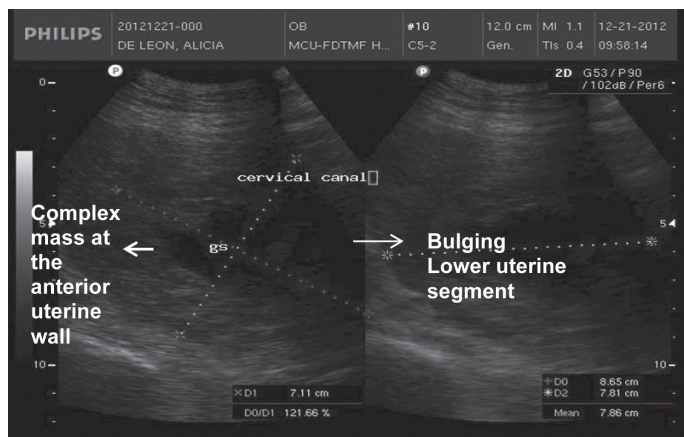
Transvaginal ultrasound image of thin intact endometrium from the midportion of the uterus to the fundus, bulging lower uterine segment with complex mass containing a collapsed gestational sac at the anterior wall measuring 8.1 x 5 x 5.9 cm. Interpreted as pregnancy of CS scar
